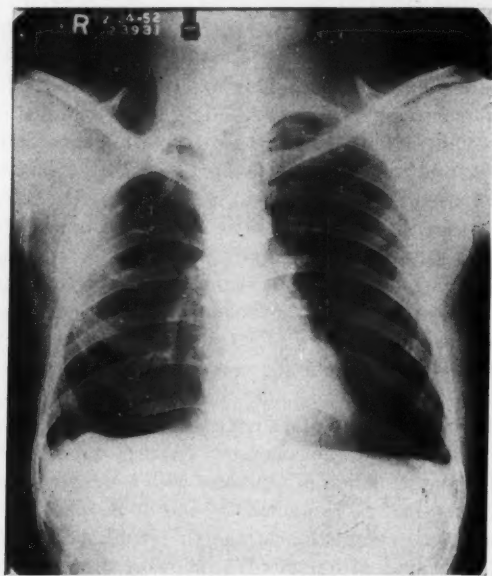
Postoperative roentgenogram four months following upper lobectomy and small apical thoracoplasty.
